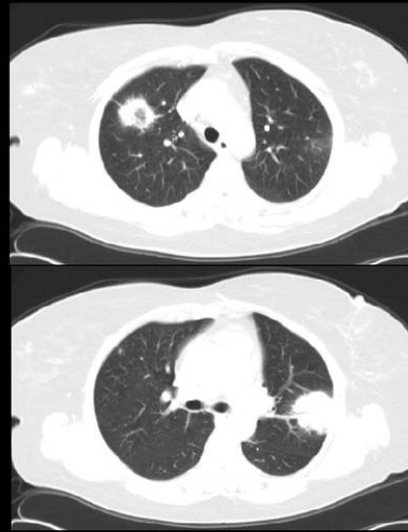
Chest radiograph and axial CT show sharply marginated nodules located in the periphery of the lung. The nodule in the right upper lobe is cavitated. The patient is a 56 year-old woman with chronic renal disease.
